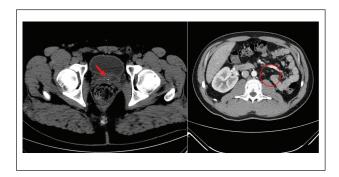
The CT scan displays the confirmed ultrasound findings, revealing an impacted stone in the left ejaculatory duct (red arrow), absence of the left kidney, and hypertrophied right kidney (red circle). CT, computed tomography.
